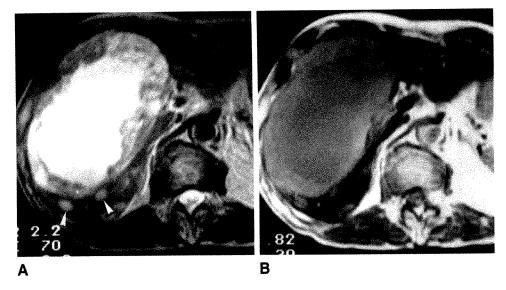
T2-weighted MR images of metastases from bronchus carcinoma.
